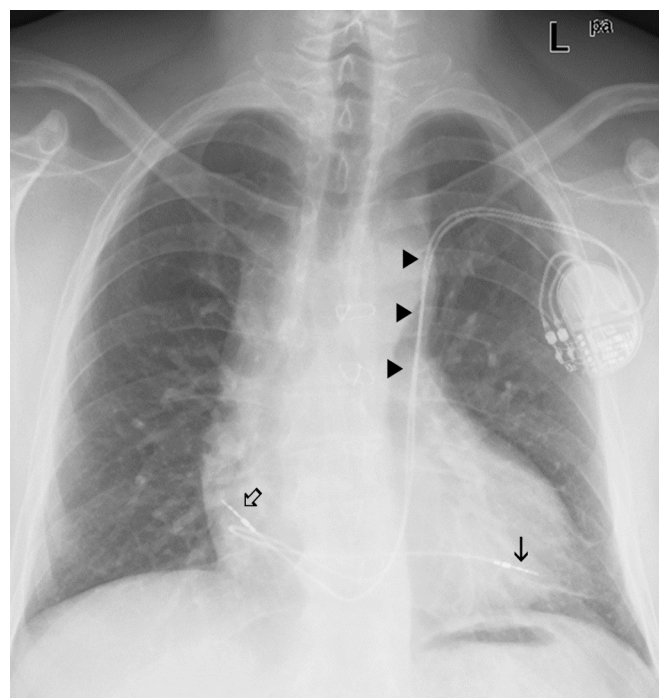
The chest radiograph after the procedure showed a left-sided path of both pacemaker leads *via* the PLSVC (arrowheads), with correct position of the tips in the right atrium (open arrow) and in the right apical ventricle (arrow), suggesting connection with the right atrium.
